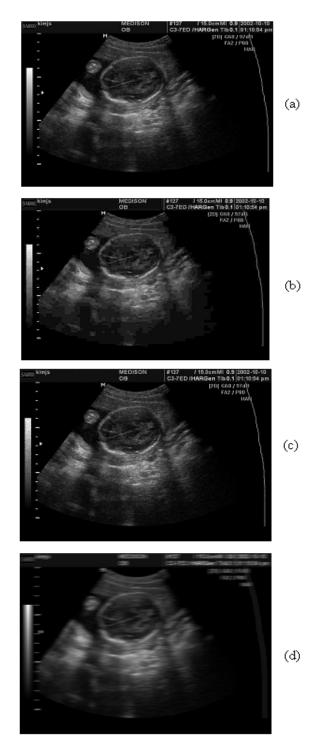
Comparison of an ultrasound image with different types of distortions, all with a PSNR value of 35 dB. (a) Original image; (b) JPEG2000 compressed image, SSIM = 0.75; (c) With speckle noise, SSIM = 0.85; (d) Blurred Ultrasound image, SSIM = 0.7.
